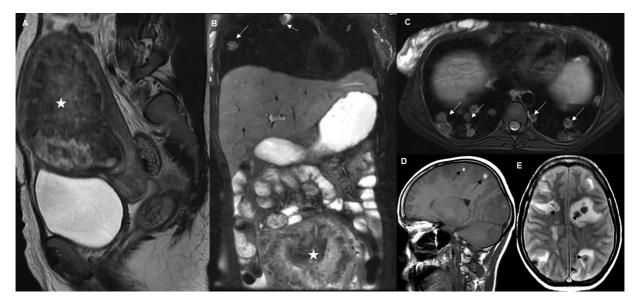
Stage IV choriocarcinoma in a 29-year-old woman with lung and brain metastases. (A) Sagittal T2-weighted (T2W) image shows heterogeneously hyperintense lesion (★) diffusely involving the entire myometrium with loss of normal zonal anatomy in a grossly enlarged uterus. (B, C) Coronal and axial T2W magnetic resonance (MR) images of the abdomen and chest show primary uterine lesion (★) and multiple lung metastases (arrows). (D, E) T1W sagittal and T2W axial MR images of the brain show hemorrhagic metastases that are hyperintense on T1 and hypointense on T2 sequences with perilesional edema (arrows).
